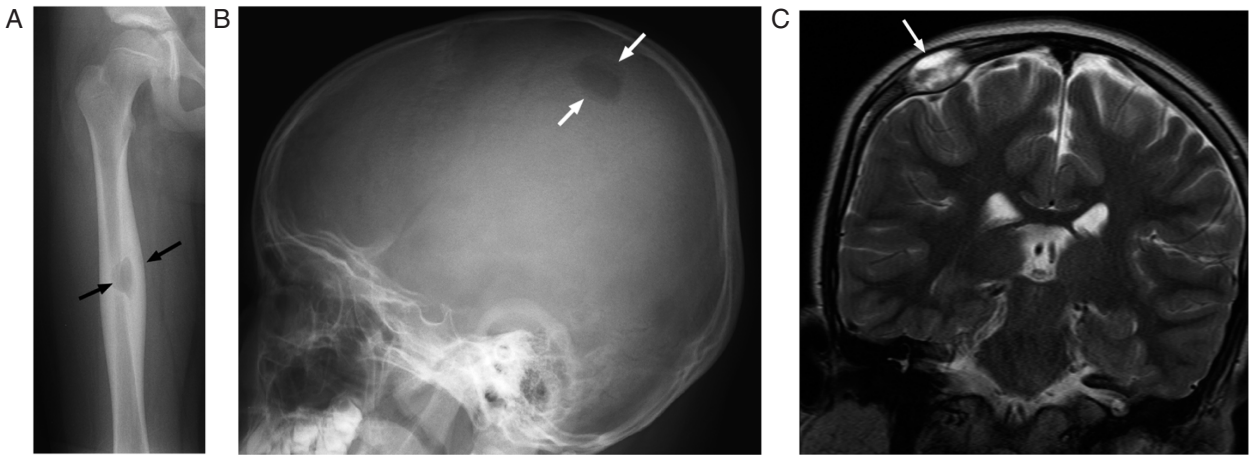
An 8-year-old girl with Langerhan's cell histiocytosis (LCH) presented with right thigh pain. (A) This anterior-posterior (AP) radiograph shows a lytic lesion surrounded by cortical thickening (arrows) in the diaphysis of the right femur. The femur is a common site of involvement in LCH. (B) The patient also had a skull lesion as shown in this lateral skull x-ray (arrows). Note the beveled edges of this lesion, a feature typical of LCH. (C) This coronal T2-weighted MRI shows the soft tissue component (arrows) of the skull lesion. The skull is the most common site of bone disease in LCH and patients often present with a palpable scalp mass.
